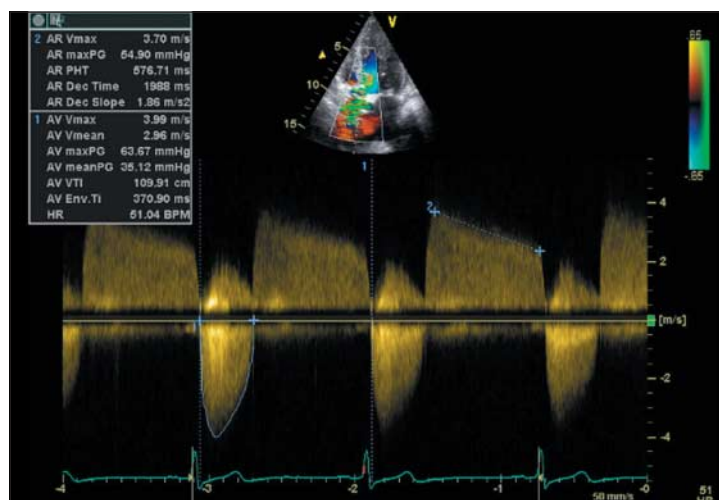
Continuous wave Doppler study of aortic valve (mixed aortic valve disease)
